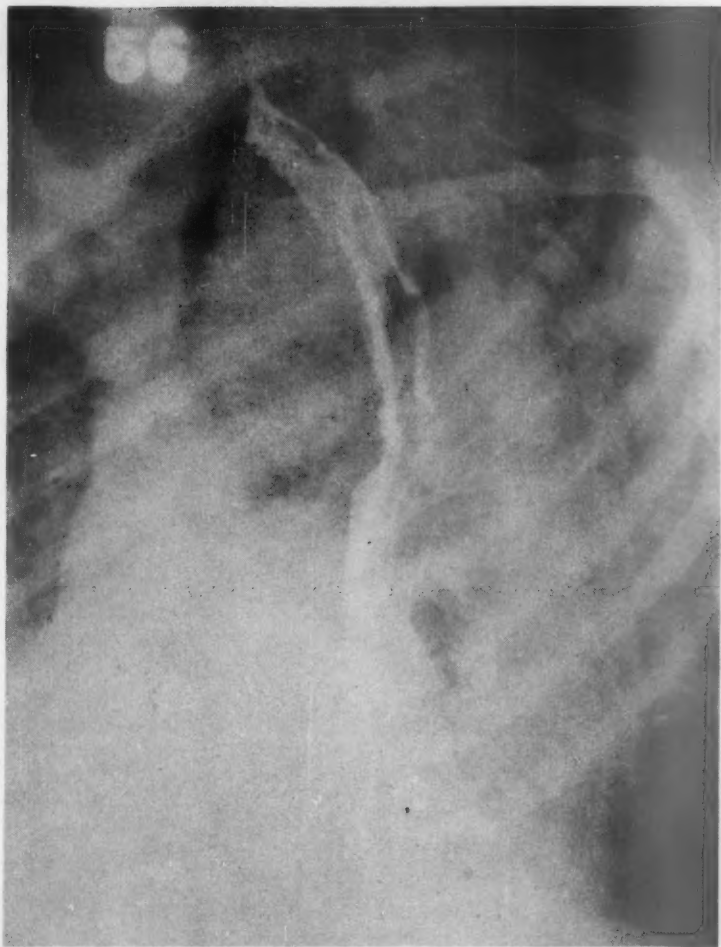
A left anterior oblique barium swallow x-ray study, showing the large anterior density. The mass is displacing the esophagus posteriorly and the trachea anteriorly. Removal was accomplished by a cervical approach.
